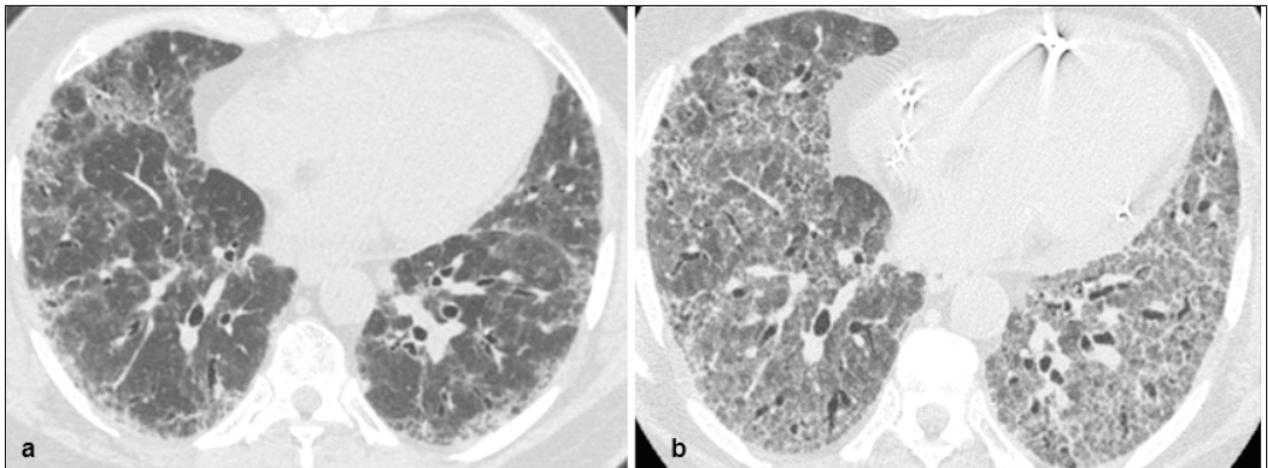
A: Axial CT of a patient with familial ILD. B: Axial CT of the same patient 6 months later at the time of an acute exacerbation and shows worsening bilateral ground-glass opacification. Abbreviation: CT, computed tomography, ILD: interstitial lung disease
